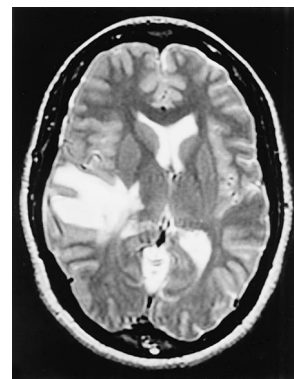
Axial magnetic resonance imaging scan of the brain, obtained approximately 6 years after the initial presentation, demonstrating a new right posterior temporal intraparenchymal hemorrhage.
